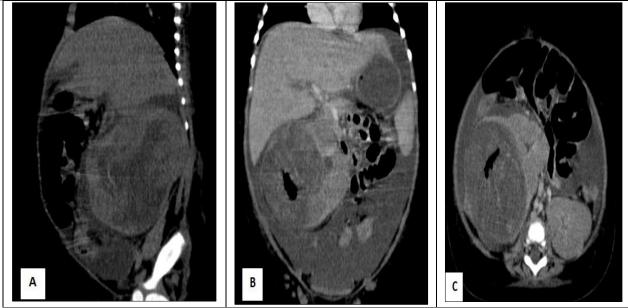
CT scan sagittal slice with non contrast intravenous (A) axial and coronal slices with intravenous contrast (B, C), shows a large right renal mass with a solid-cystic appearance, extensively necrotic, containing air bubbles, associated with a large amount of peritoneal effusion
